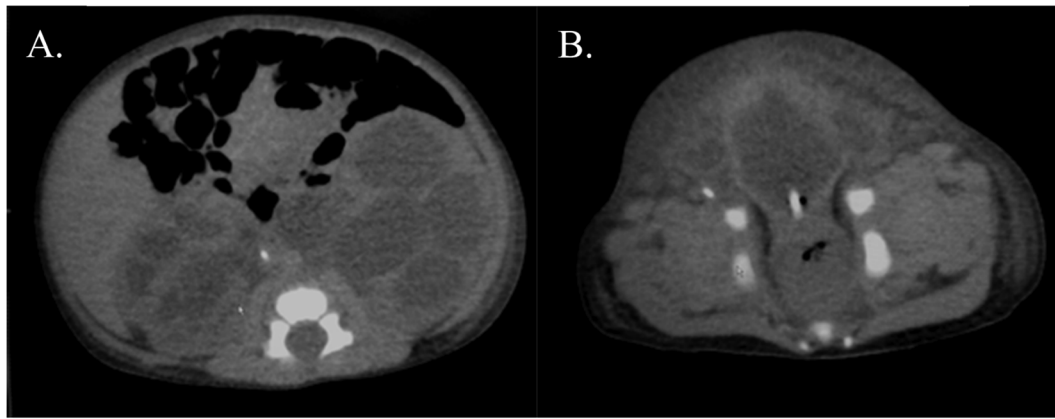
Plain computed tomography revealed: A. bilateral hydronephrosis in the upper urinary tract, and B. non-distended bladder.
